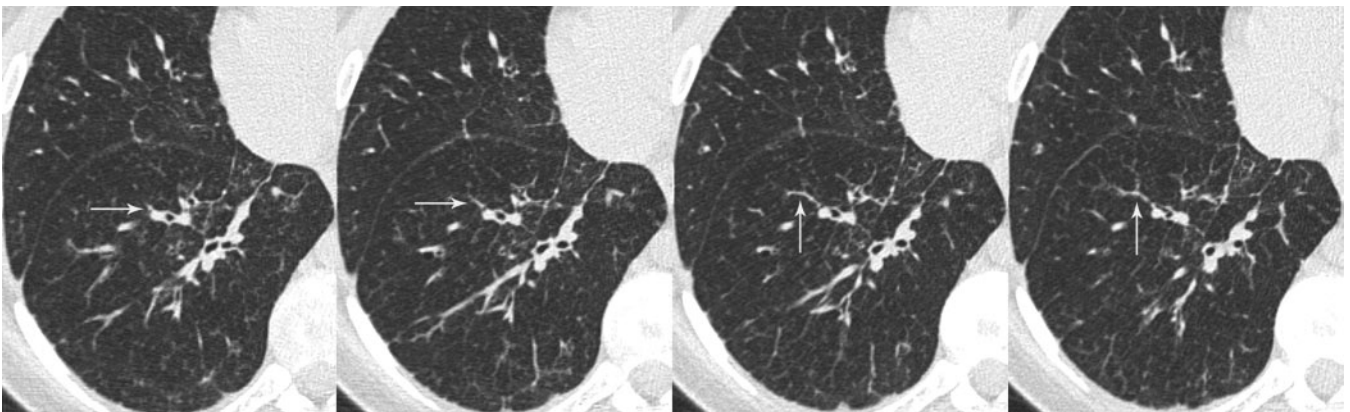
Sequential magnified views of the right lower lobe from a 64-track multidetector row CT pulmonary angiogram demonstrate a small subsegmental pulmonary artery coursing within the interlobular septa (arrows). Also noted is mild interlobular septal thickening.
